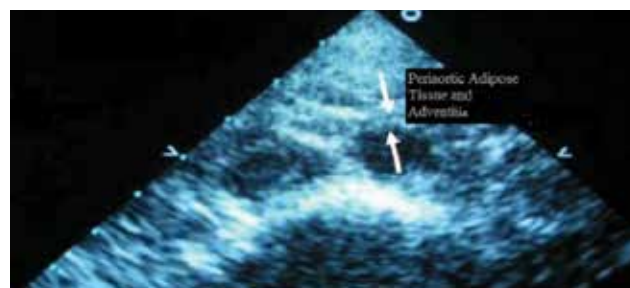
Image of periaortic adipose tissue and adventitia on echocardiography
